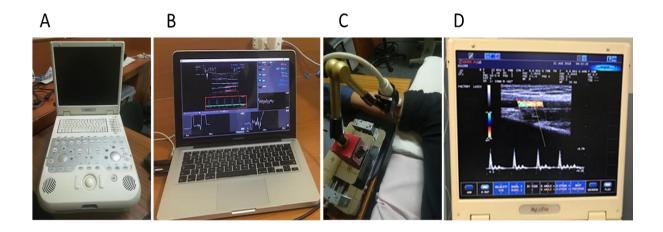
Photographs of the instruments used for FMD measurements. A) Esaote MyLabTM Five portable ultrasound device (Genoa, Italy); B) Apple MacBook Pro laptop (2010 edition) with software with edge detection technology (Quipu Cardiovascular Suite[™]; Pisa, Italy); C) Probe holder from SMT Medical (Wuerzburg, Germany) with an Esaote Doppler probe (LA523, 12 MHz) attached. D) Doppler mode on the ultrasound, displaying image in colour. Photographs were taken by the author of this dissertation.
